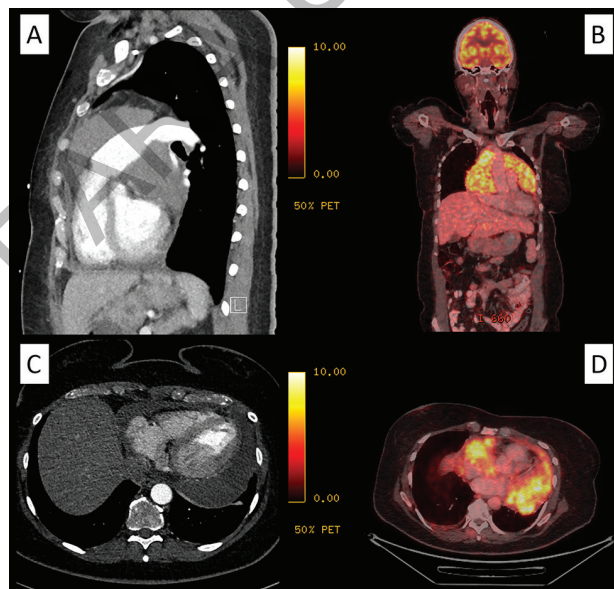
Contrast-enhanced CT scanning and ^{18}F -FDG PET scanning. (A) CT scan, sagittal view; (B) ^{18}F -FDG PET scan, frontal view; (C) CT scan, axial view and (D) ^{18}F -FDG PET scan, axial view.
